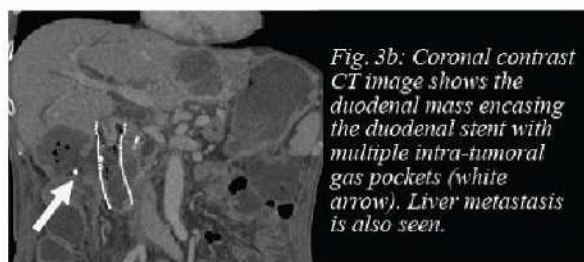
Coronal contrast CT image shows the duodenal mass encasing the duodenal stent with multiple intra-tumoral gas pockets (white arrow). Liver metastasis is also seen.
